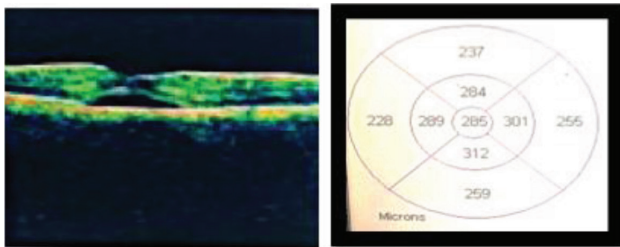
FUNDUS PHOTO WITH CORRESPONDING OCT AND FFA PICTURES OF RE AND LE RESPECTIVELY. RT. EYE SHOWING RING REFLEX & CLASSICAL SMOKE STACK PATTERN SUGGESTIVE OF CSR
